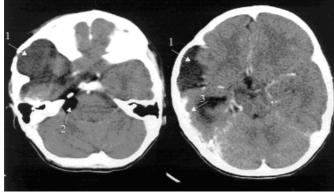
CT scan of the head. On the left, a slice showing an arachnoid cyst on the temporal fossa, expanding the cranial vault (arrow 1), associated with temporal lobe atrophy. Adjacent to the petrous bone there is a lipoma (arrow 2). On the right a slice showing the superior portion of the arachnoid cyst and cortical enhancement with vascular shape on the posterior temporal lobe (arrow 3).
